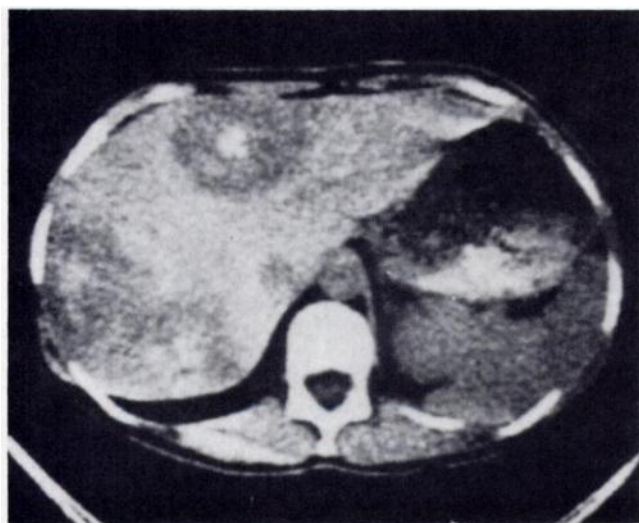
CT scan showing metastatic adenocarcinoma from colon. Central foci of increased density within predominately low density metastatic tumors believed to be blood within areas of necrosis. Dense material in stomach probably caused by ingested meat.
